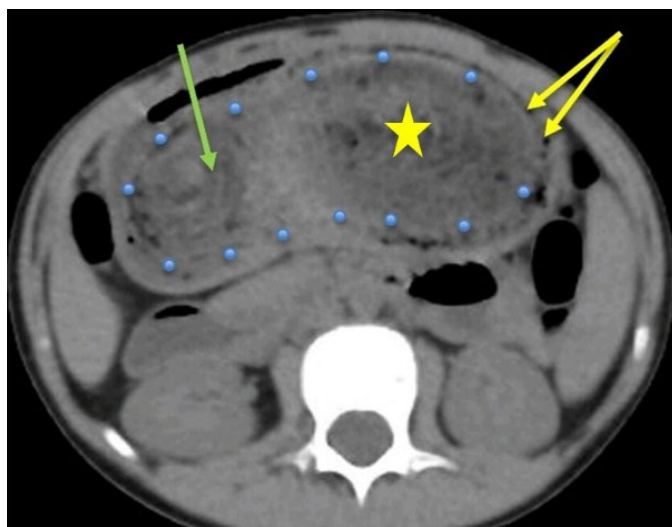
Abdominal CT scan: granular (green arrow), with air (yellow arrows), and solid material molding the stomach (blue dots).
